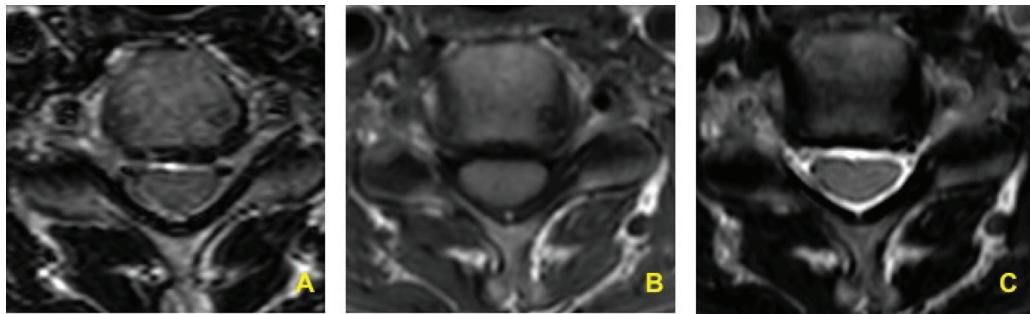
A 68-year-old female patient with cervical radiculopathy. MRI shows grade 2 cervical neural foramen stenosis (moderate CNFS) on the left side in (A) axial 2D T2W image, (B) axial 3D T1W image, and (C) axial 3D T2W image.
